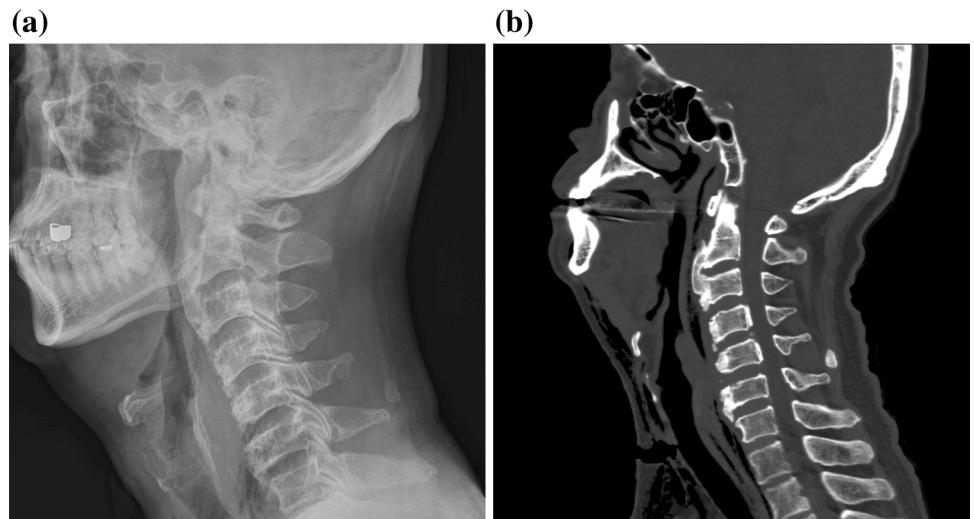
Preoperative cervical simple X-ray (a), CT (b), and MRI (c) showed severe OALL from C2 to C7
